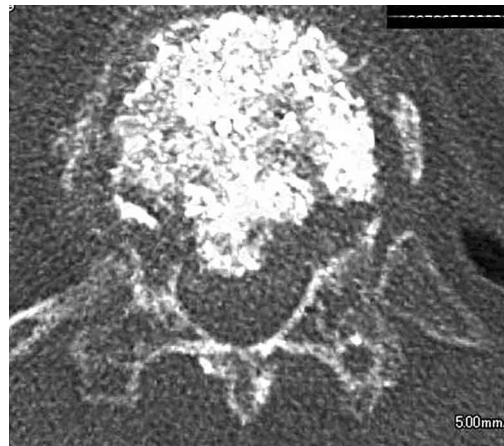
CT scans showing extravasation of PMMA cement into the vertebral canal.
